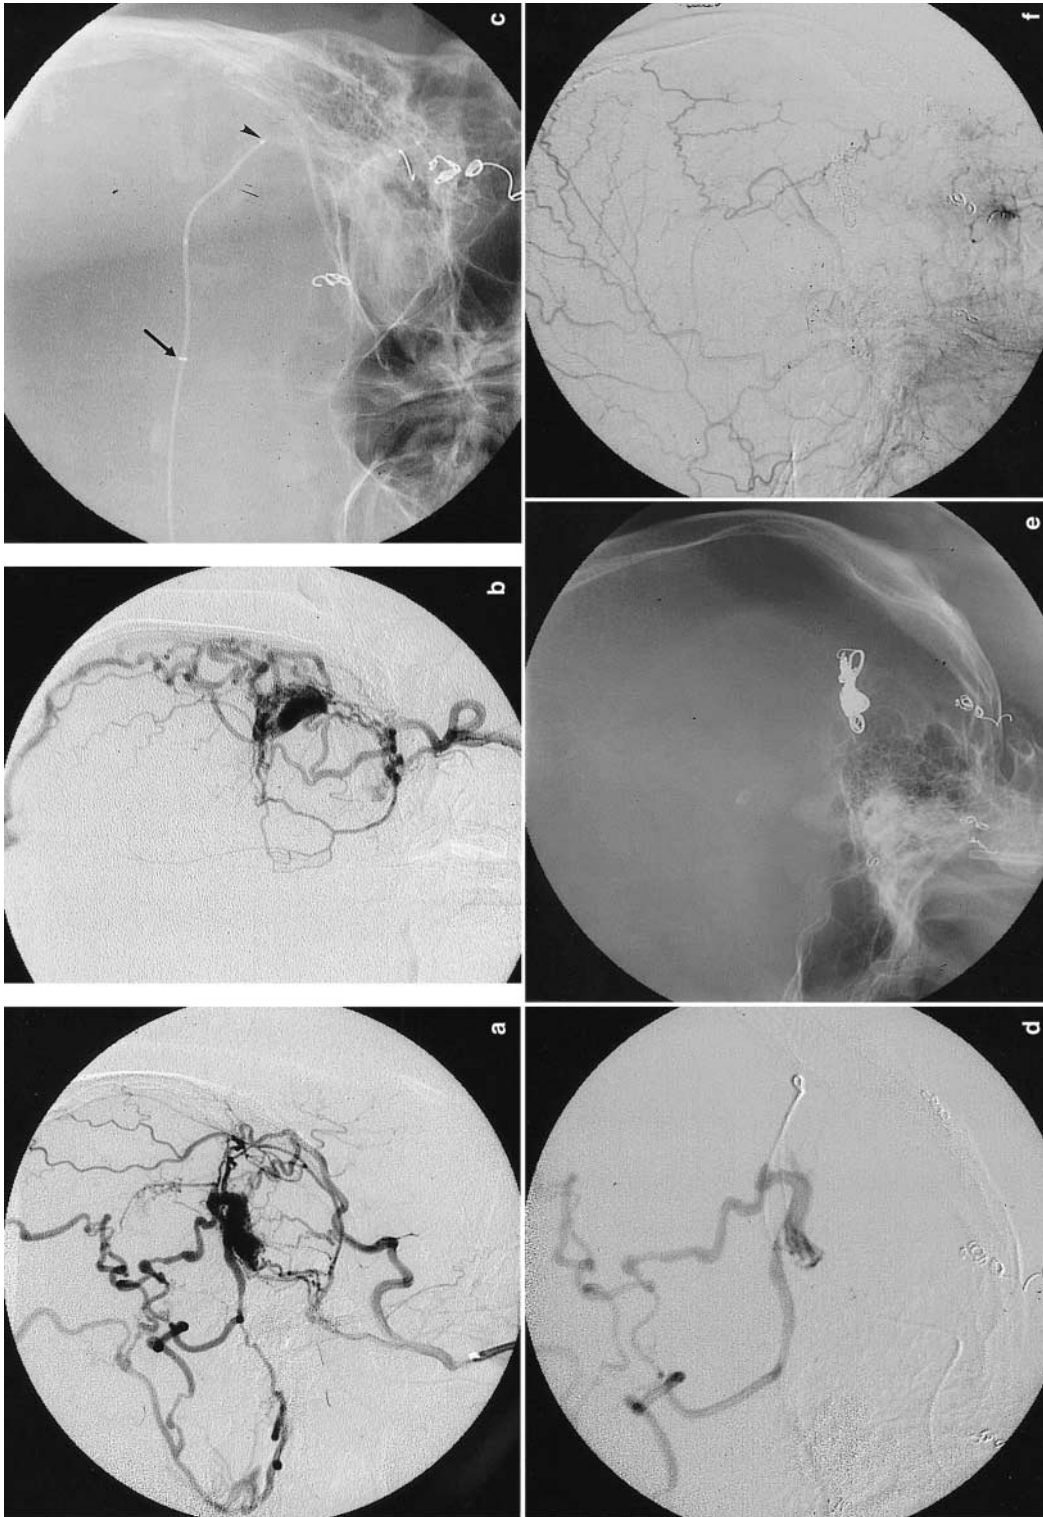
Case 1: A 50-year-old man presenting with transient ischaemic attacks of motor aphasia due to brain edema in the left temporo-occipital region. Pre-embolisation left occipital artery injection (A: lateral view, B: frontal view) shows a dural AVF involving the left isolated transverse-sigmoid sinus. Venous drainage is solely retrograde and leptomeningeal. Plain x-ray film (C: frontal view) shows transfemoral, transvenous catheterisation to the isolated sinus with a microcatheter traversing through the torcular Herophili and occluded proximal transverse sinus. The arrow indicates the tip of the Tracker-38 catheter and the arrowhead indicates the tip of the microcatheter. Sinography (D: lateral view) shows a leptomeningeal venous drainage. Post-embolisation plain x-ray film (E: lateral view) shows the deposited coils. Post-embolisation left external carotid injection (F: lateral view) fails to show the dural AVF
